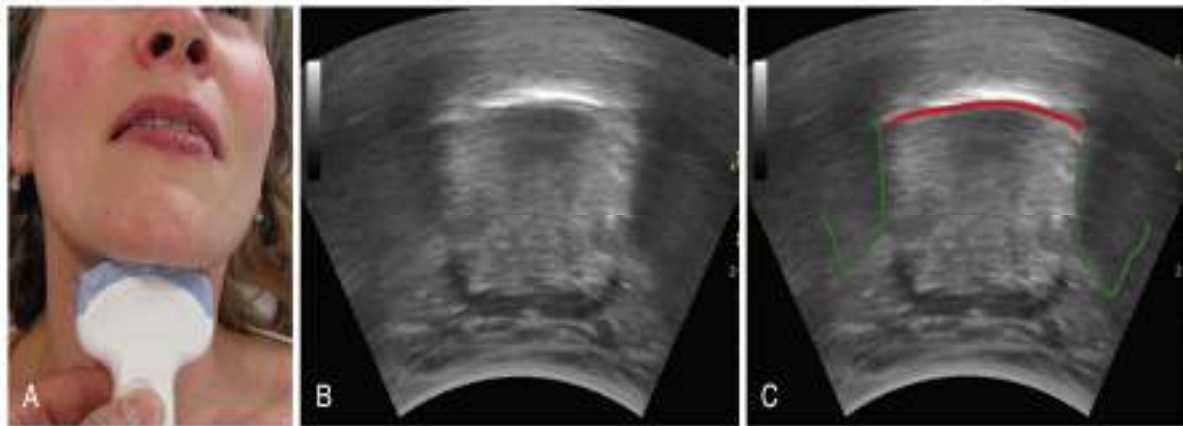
Transverse scan of the floor of the mouth and the tongue. (A) Placement of the transducer. (B) The resulting ultrasound image. (C) The dorsal surface of the tongue is indicated by a red line, and shadows arising from the mandible are outlined
